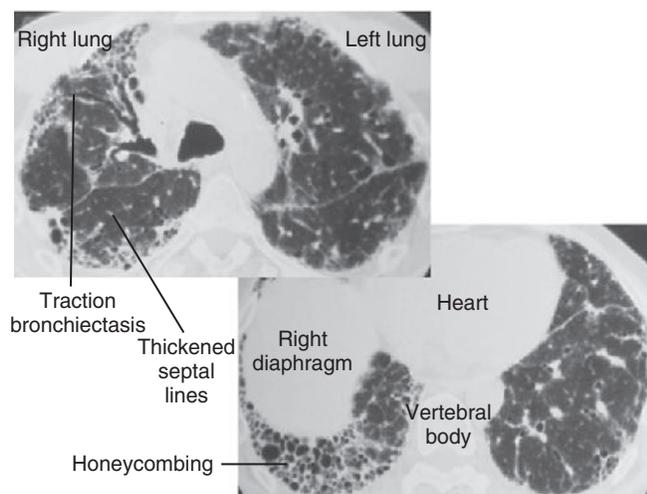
Computed tomography of the chest of a patient with idiopathic pulmonary fibrosis.
